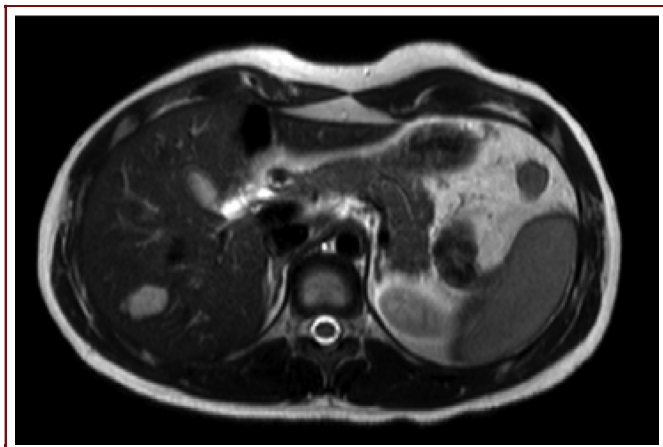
Hepatic MRI: hepatic lesion with hypersignal in T2 ponderation, corresponding to a provable fibrosing hemangioma.
